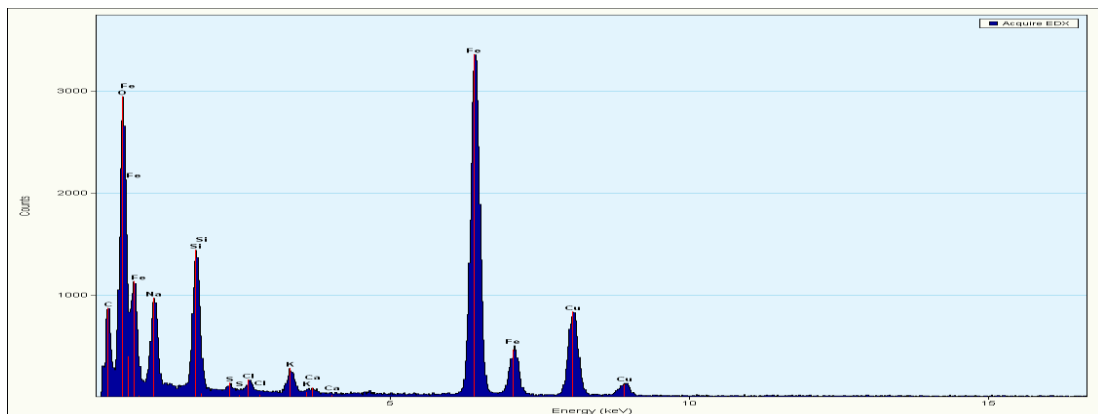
Energy Dispersive X-Ray analysis of silica coated SPIONs (9s).
